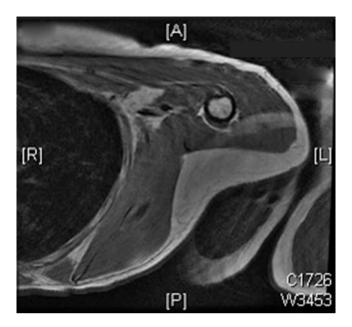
T1 weighted axial MRI image of an intramuscular lipoma of the trunk
